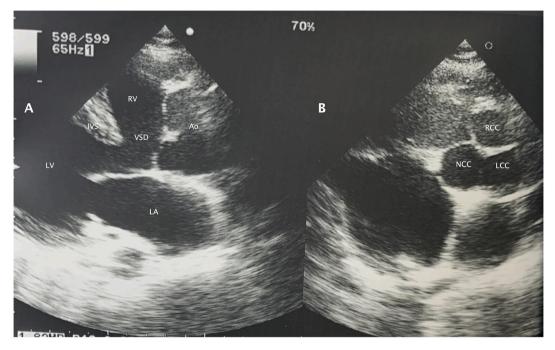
(A) Parasternal long-axis echocardiographic view, showing large ventricular septal defect and dilated ascending aorta overriding the interventricular septum. (B) Parasternal short-axis view, showing three dilated aortic cups. Ao, aorta; LA, left atrium; LCC, left coronary cusp; LV, left ventricle; NCC, noncoronary cusp; IVS, interventricular septum; RCC, right coronary cusp; RV, right ventricle; VSD, ventricular septal defect.
